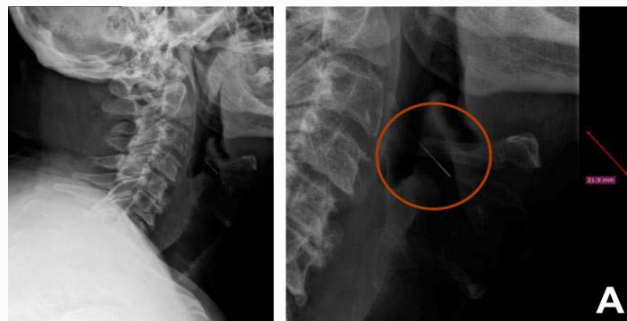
On the left, cervical X-ray showing a metallic needle-shaped foreign body in the larynx; on the right enlarge detail of dangerous foreign body in the larynx.
